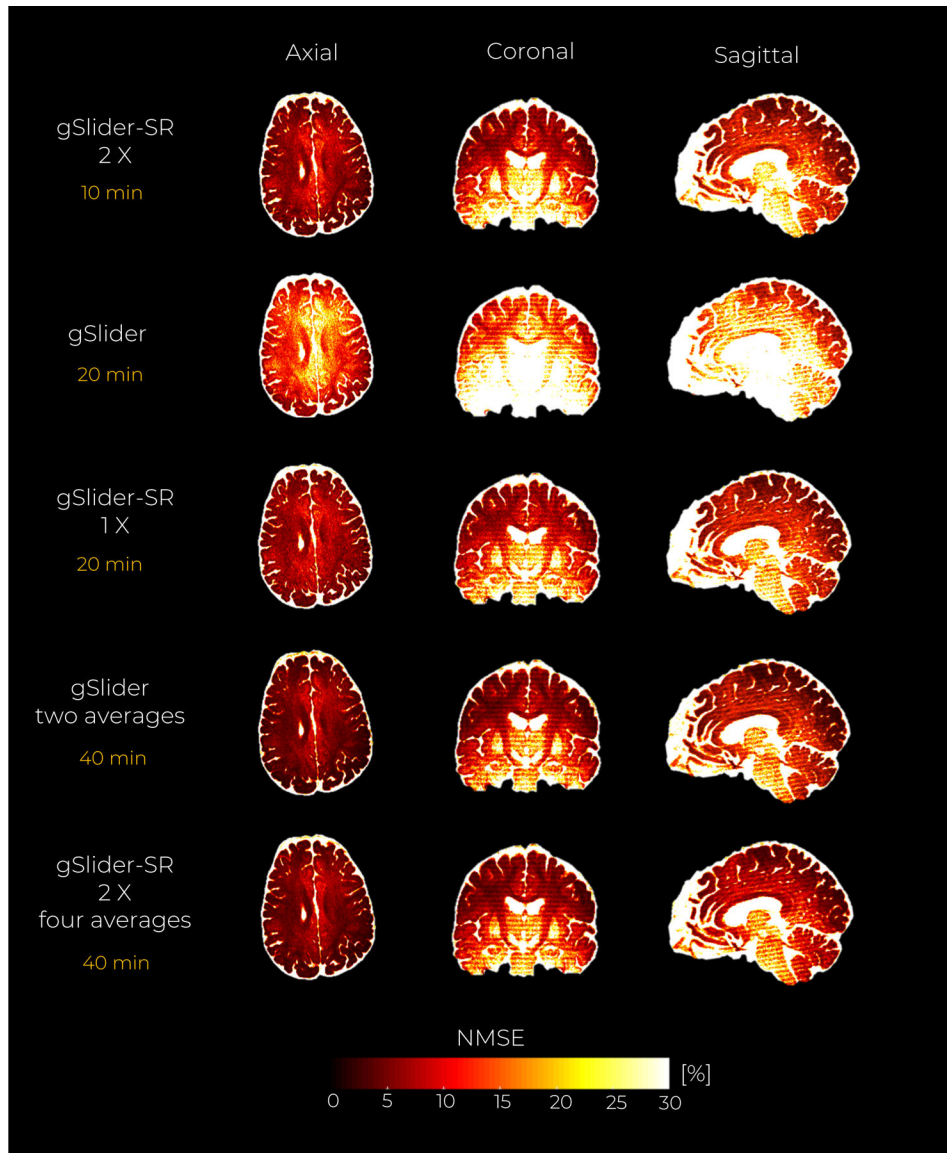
In vivo data experiment with an acceleration factor of 2X. An axial, coronal and sagittal slice of the NMSE maps from the reconstructed DWI volumes are shown for the gSlider, and gSlider-SR based reconstruction, respectively
